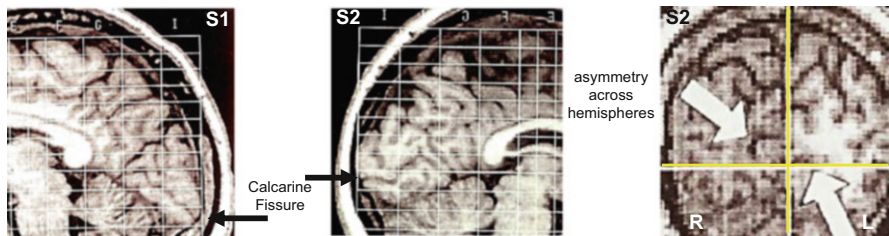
shows how cortical geometry differences can exist across participants even for a prominent fissure in cortex such as the calcarine fissure. Sample MRIs for two participants show how the fissures differ (i.e., follow the fissure from the black arrows starting at the occipital pole up to the parieto-occipital sulcus). In this example, the MRIs were placed into Talairach space, a space used for roughly equating brain regions across subjects. However, there is about a 2 cm difference, between subjects, in terms of where the calcarine fissure meets the occipital pole (black arrows). The MRI at right shows that even within a single participant, MEG
